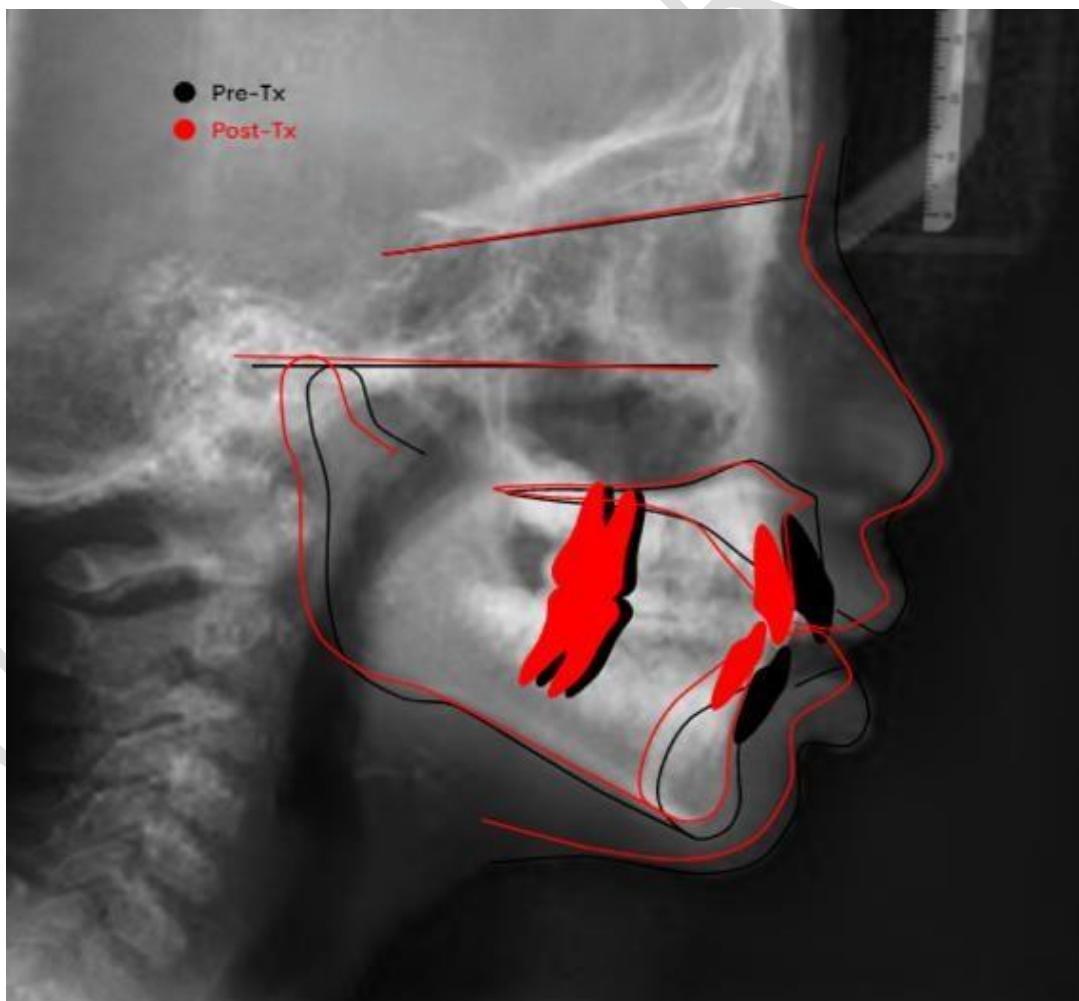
Superimposition of pre and post treatment lateral cephalometric radiographs
